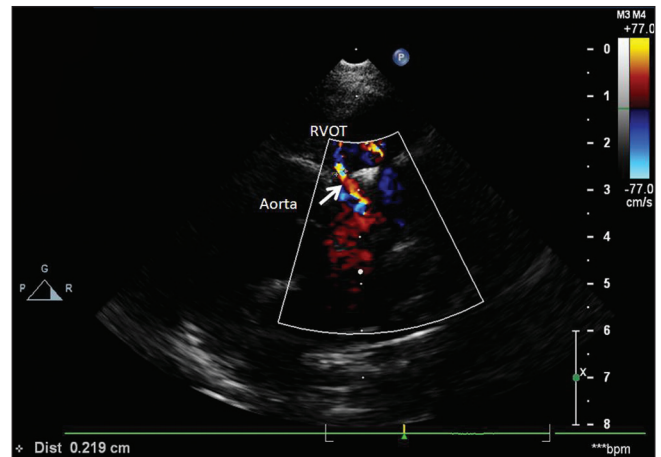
Parasternal short axis view demonstrating pulmonary regurgitation (arrow) at 1 year follow-up
